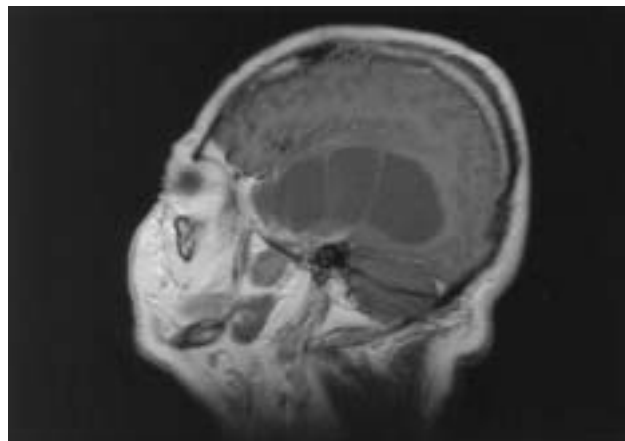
Sagittal view of brain T1-weighted MRI showed huge cyst with multiple septula.
